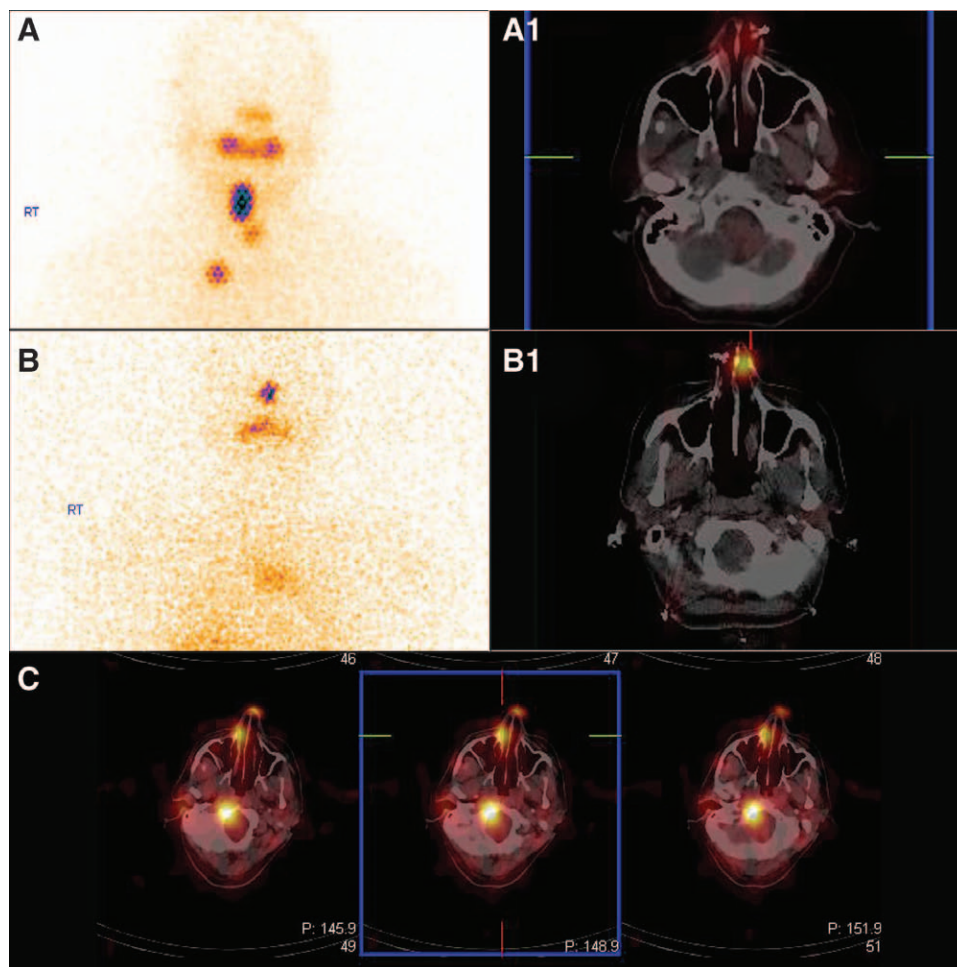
I-131 SPECT-CT: A, 60-year-old female patient of papillary carcinoma, post administration of 100 millicurie of I-131. Note the low uptake on head and neck window of planar I-131 scintigraphy (A). Note the low, diffuse nasal uptake on axial cut section of SPECT-CT (A1). B, 29-year-old female patient of follicular carcinoma, postadministration of 150 millicurie of I-131. Note the moderate uptake on the head and neck window of planar I-131 scintigraphy (B). Note the moderately intense nasal uptake on axial cut section of SPECT-CT (B1). C, 60-year-old male patient of papillary carcinoma, postadministration of 150 millicurie of I-131. SPECT-CT, serial axial cuts showing high uptake of the nasal tip, septum and right nasal cavity and lateral walls (C). SPECT-CT, single photon emission computed tomography.
